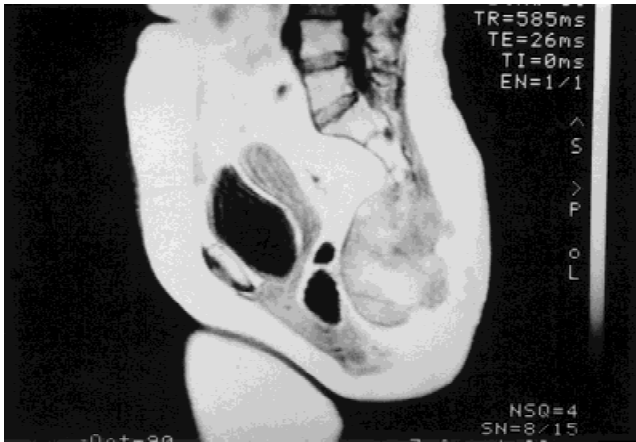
Midline sagittal T1-weighted magnetic resonance image of an S3 chordoma. The tumor has a large presacral extraosseous soft-tissue mass that extends to the coccyx and S2.
